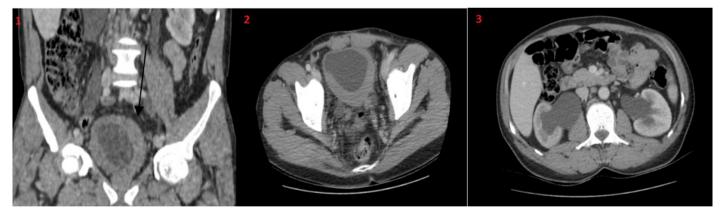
(1-2) Diffuse bladder wall thickness increase in preoperative computed tomography, (3) bilateral hydronephrosis view
